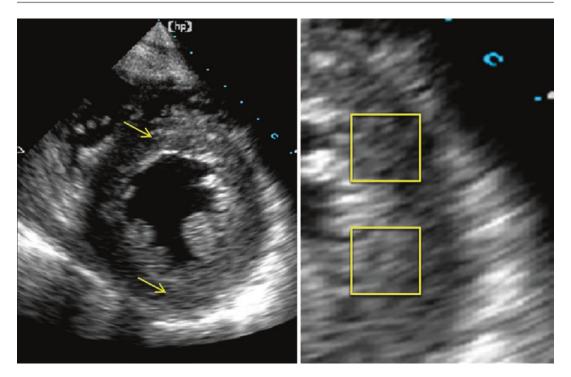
Left panel shows the short axis of the left ventricle emphasizing that speckle is the acoustic signature that is displayed in the ultrasound picture. While the quality of this image is good, speckle can be from real anatomic targets, noise and artifact. The ultrasound machine
